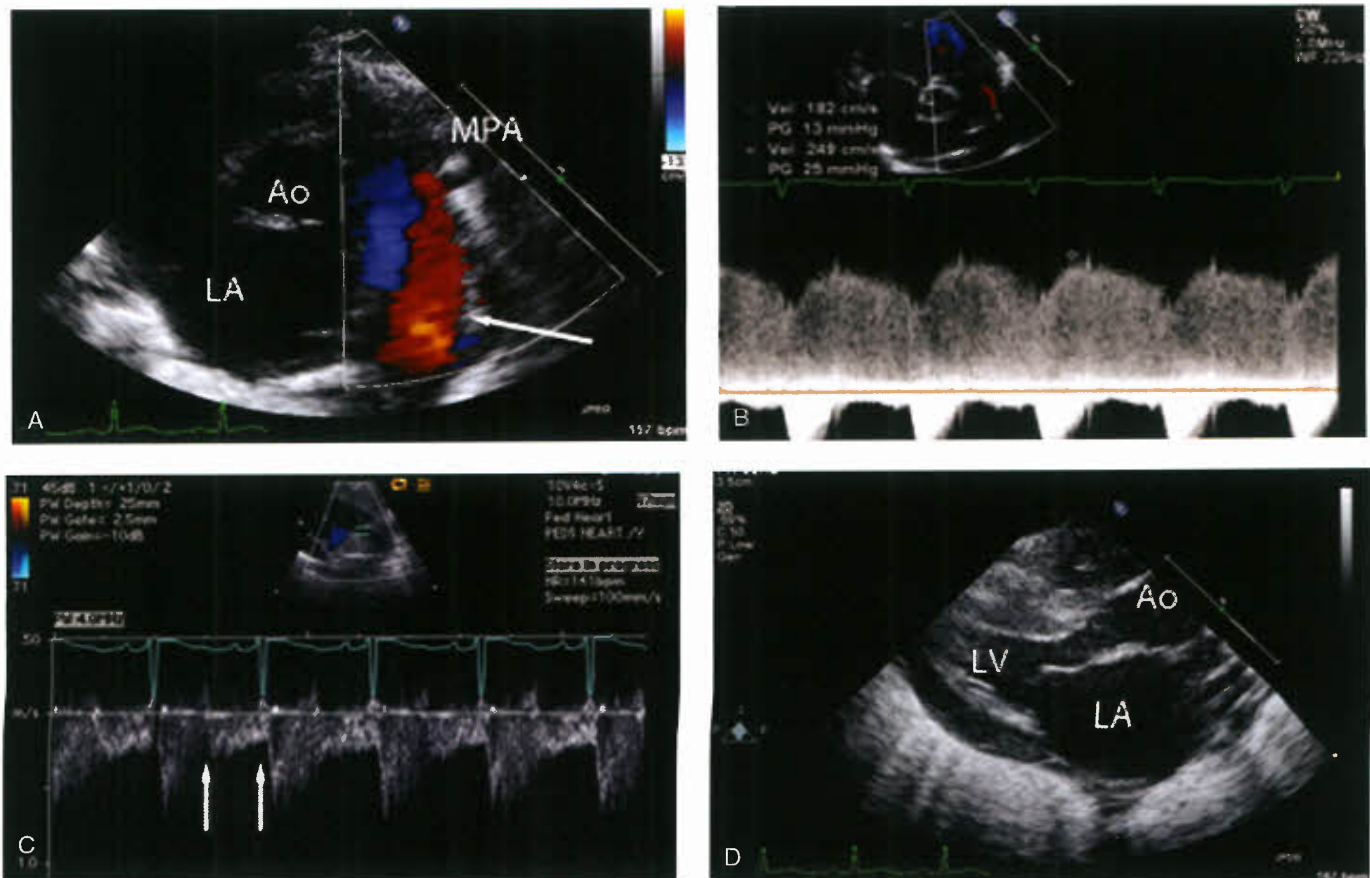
A: Echocardiogram in parasternal short axis demonstrating a patent ductus arteriosus with color-flow mapping indicating reversed flow. B: Continuous wave Doppler echocardiogram positioned through the PDA, showing retrograde flow throughout the cardiac cycle. C: Pulsed-Doppler echocardiogram shows increased diastolic flow in the branch pulmonary artery. D: Parasternal long axis showing LA and left ventricular enlargement.
